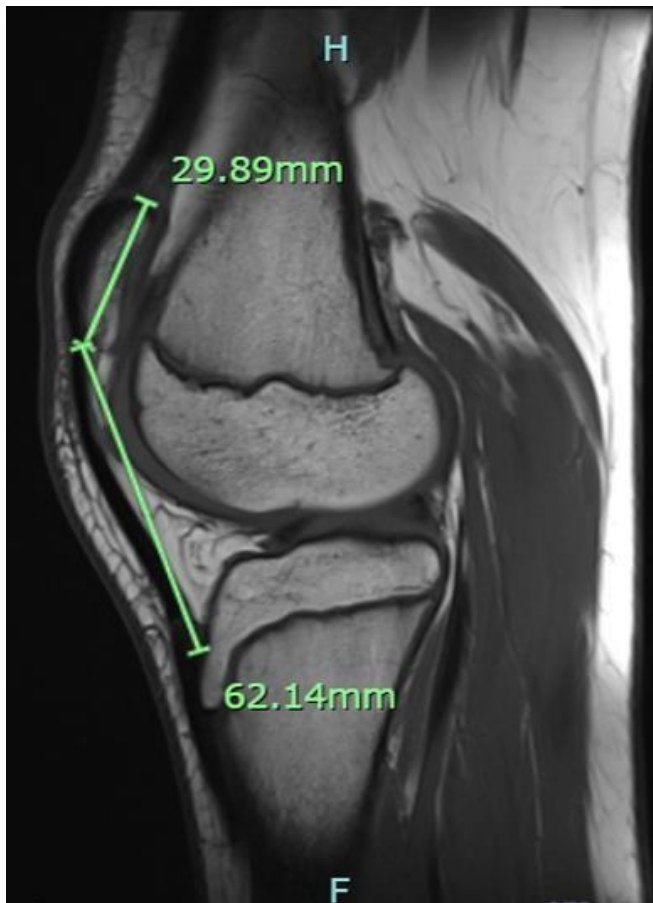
An MRI sagittal image showing patella alta with an insall-salvati ratio of 2.07 (62.14/29.98)
